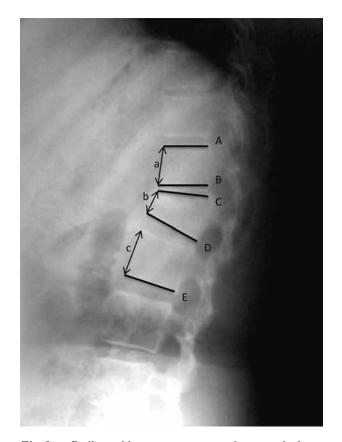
Radiographic measurements are shown on the lateral radiograph. Sagittal index was measured as described by Farcy *et al* (10); angle between lines B and D. Cobb angle is the angle between lines A and E. Local kyphosis angle is the angle between lines C and D. Anterior body height compression was calculated by referring the anterior body height of the fractured vertebral body (b) to the average anterior body height of the intact vertebral body above and below the fracture (a,c).
